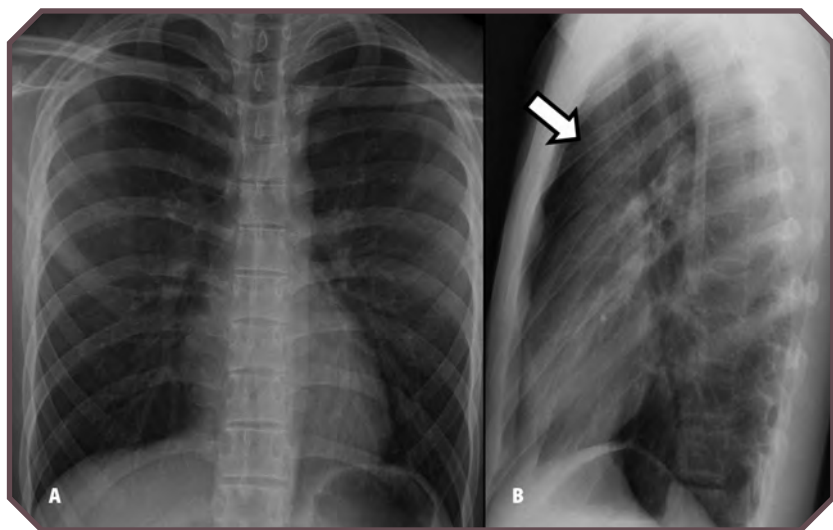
Chest radiograph in a 13-year-old boy with a history of DiGeorge syndrome. A. Frontal radiograph shows a narrow mediastinum with no thymus. B. Lateral radiograph demonstrates the absence of normal thymic shadow behind the sternum (arrow).
